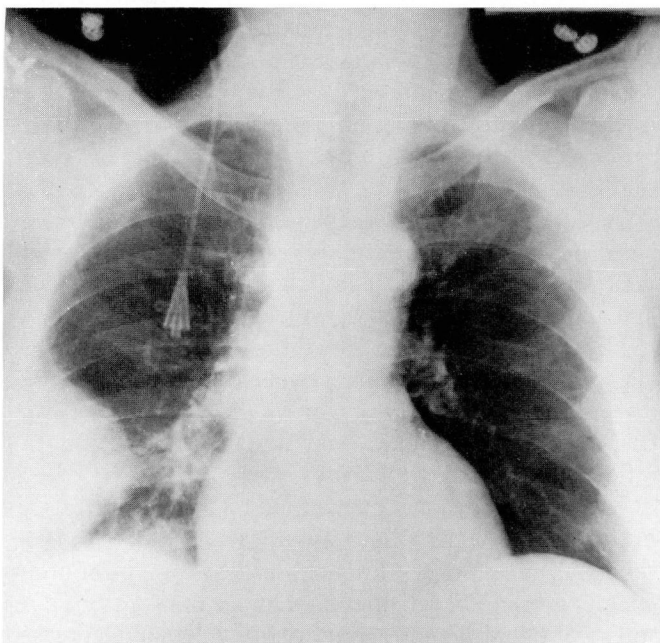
Chest radiograph reveals a peripheral dome-shaped density with apex pointed toward the hilum (Hampton's hump) and involving the right lung. The patient presented with dyspnea, pleuritic pain, hemoptysis, and wheezing.
